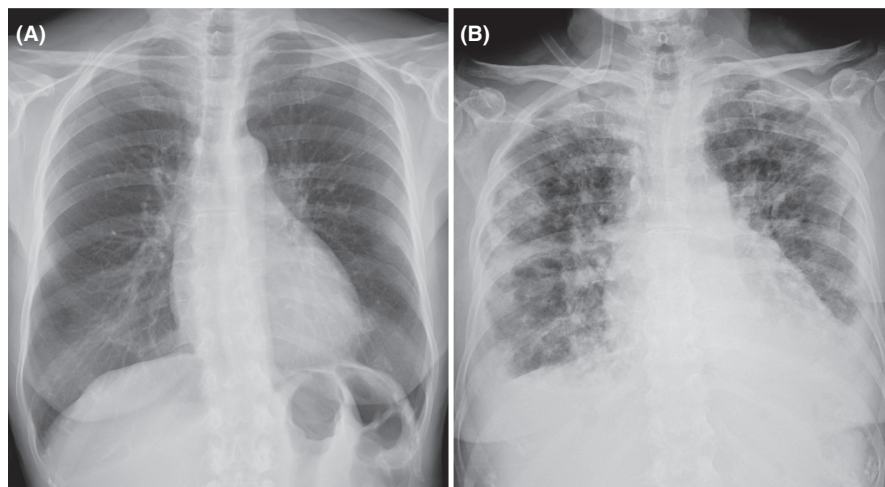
(A) Chest radiograph showing no pulmonary lesions on admission. (B) Chest radiograph 2 months after venlafaxine treatment showing bilateral multiple opacities
